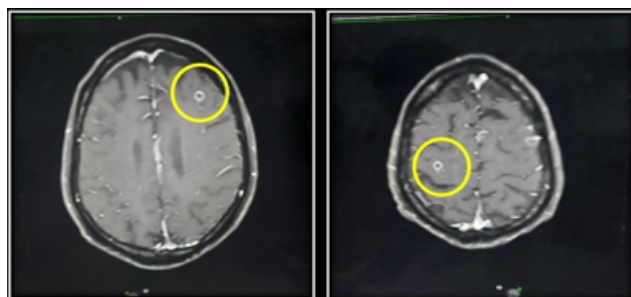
MRI Scan of brain showing intra-axial ring enhancing lesions
